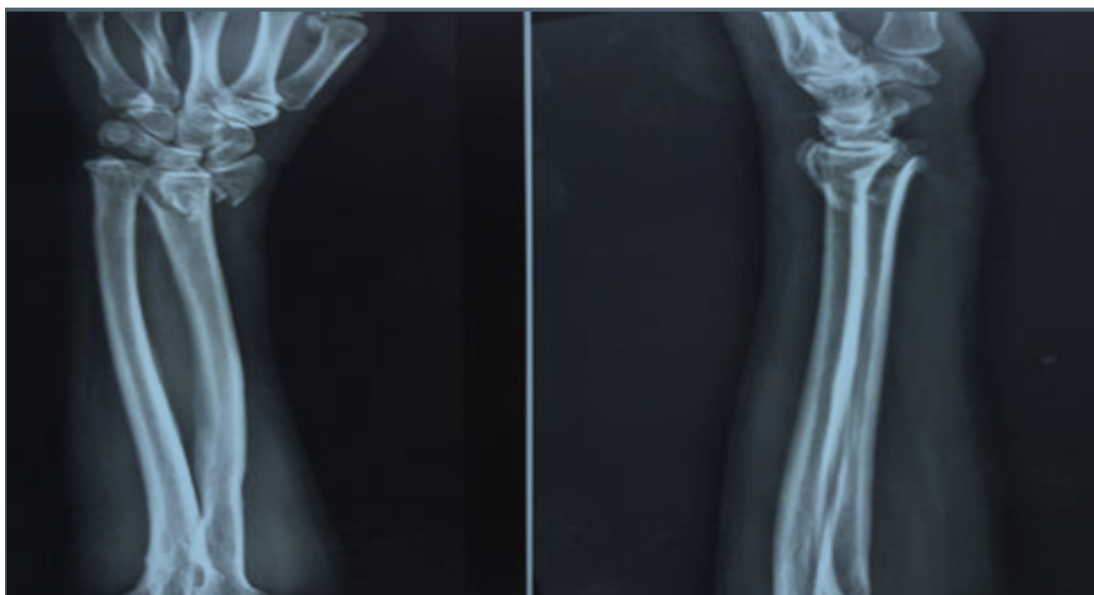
shows pre-operative x-ray of distal radius
